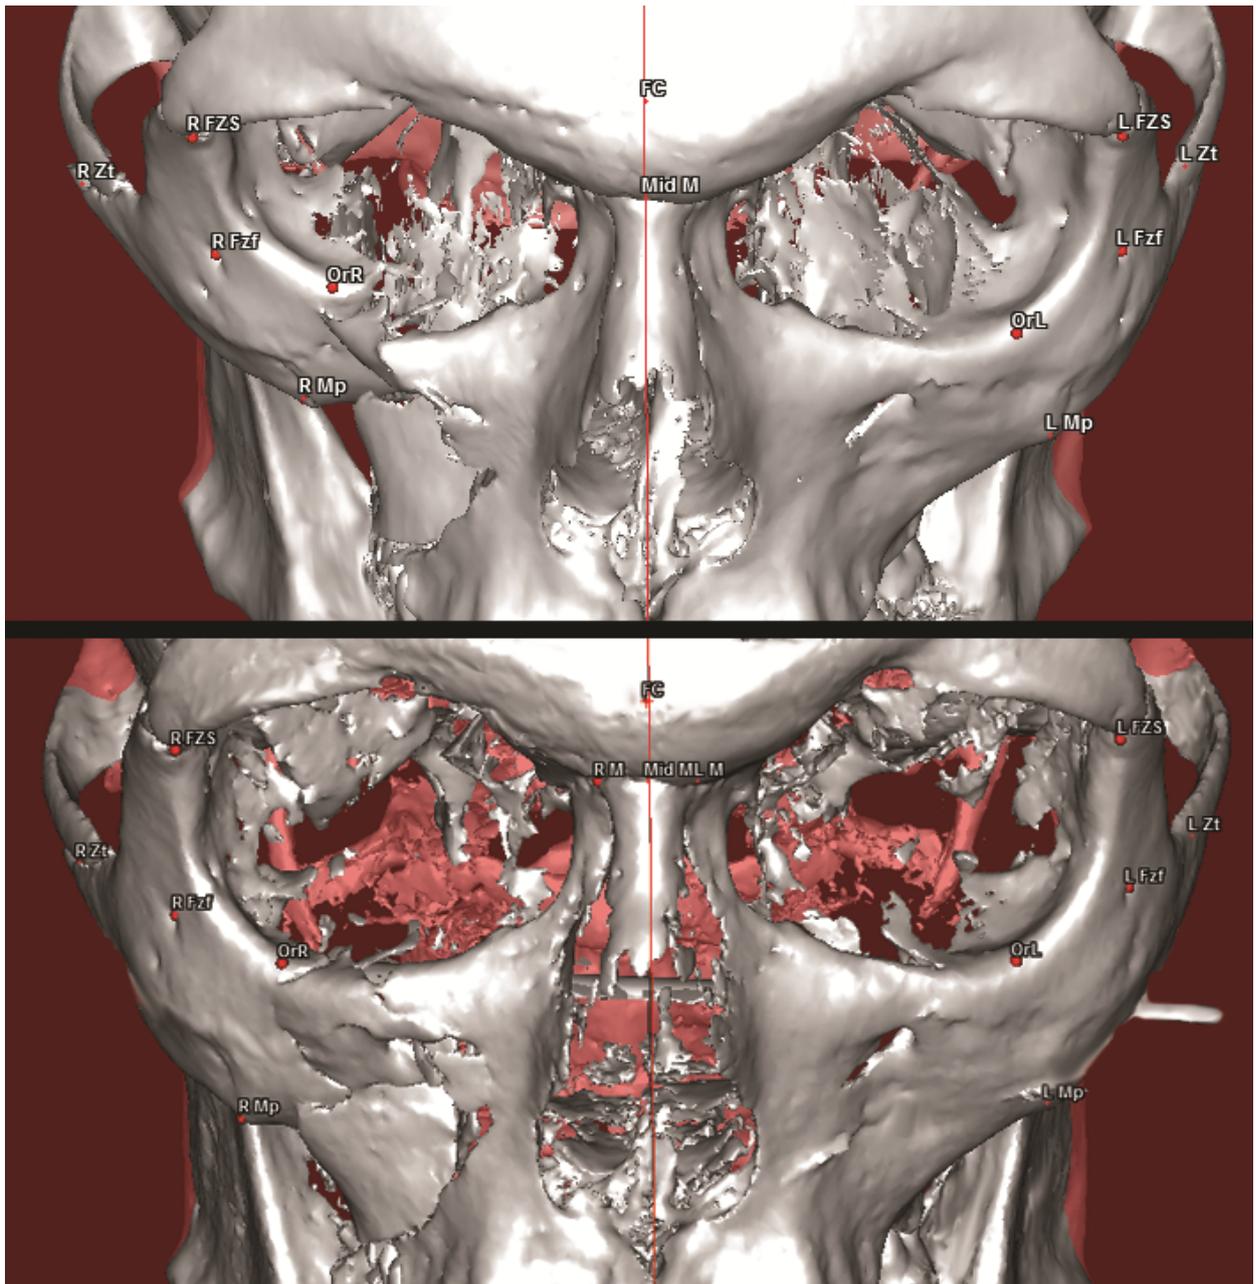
Ct-scan and CBCT 3D reconstruction, comparison before and after surgery with CRWF technique. Up: before surgery. Down: after surgery.
